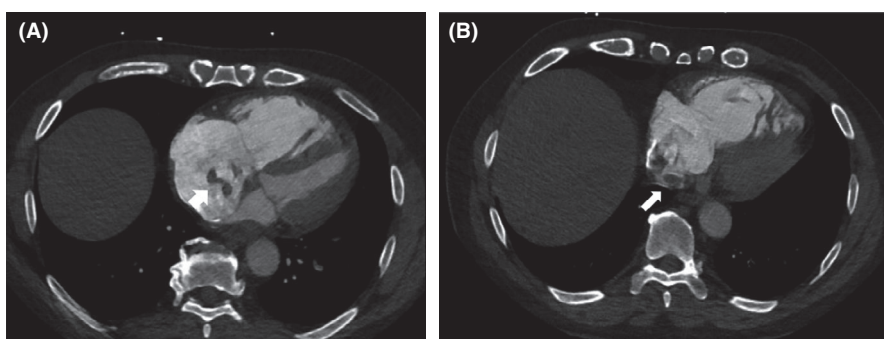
a. b. Axial CT sections showing the 4 chamber view of heart showing the right atrial clot in transit (White arrows) and the abnormal high RV/LV diameter ratio > 1 suggesting right heart strain
